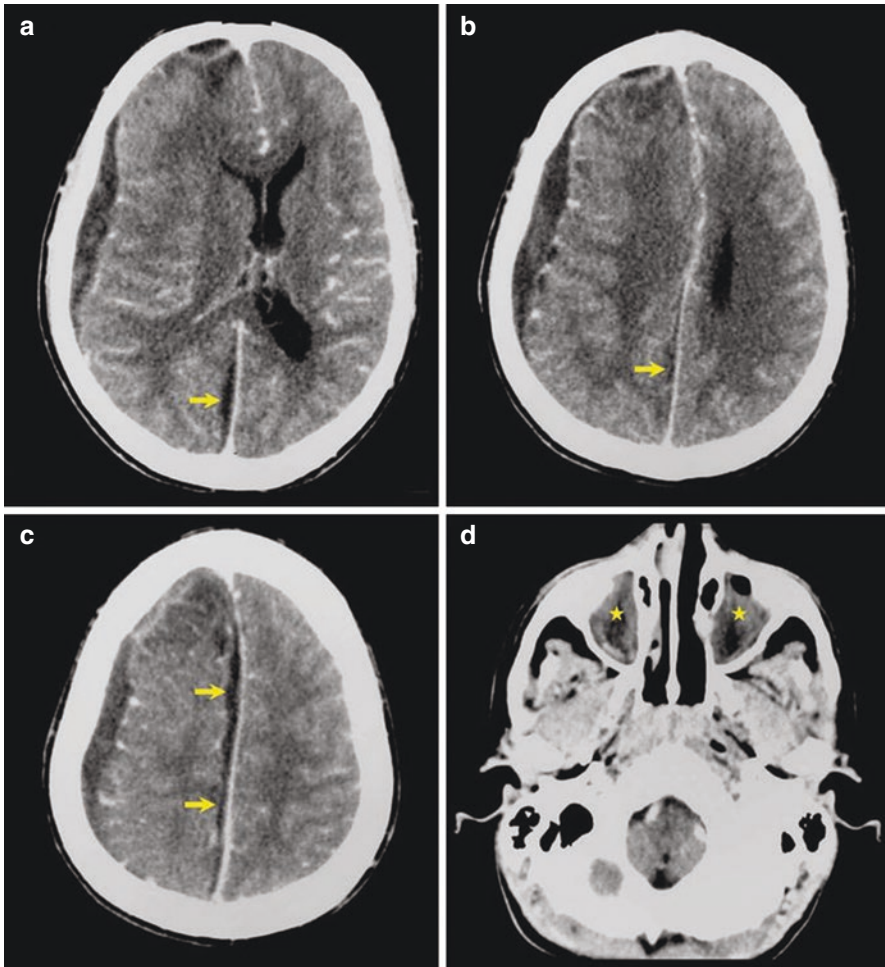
Case 6.5. (a–d) Axial cranial post-contrast CT scan showing extensive frontoparietal and interhemispheric subdural empyemas on the right side (*arrows*). Note bilateral maxillary sinusitis (*stars*)
